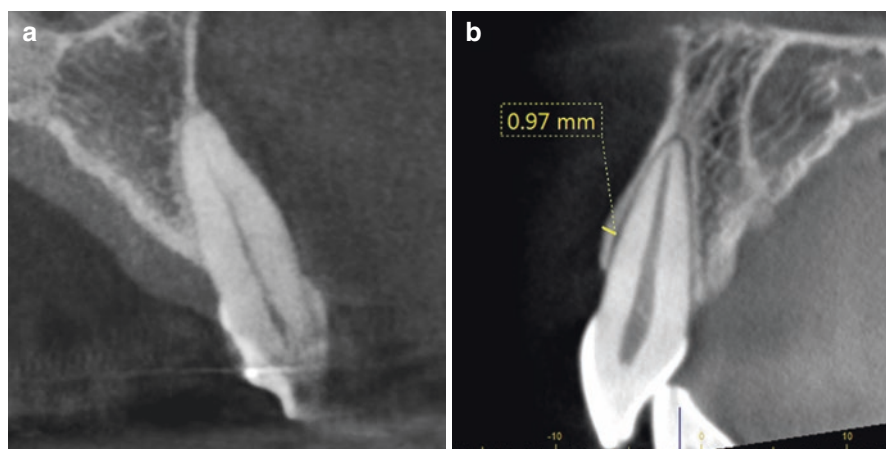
Cross-sectional CBCT images showing marked variation in labial cortical thickness. (a) A likely dehiscant labial cortex along the root of tooth #7. (b) A thicker labial cortex along the root of tooth #9 measuring approximately 1 mm in the cervical area
